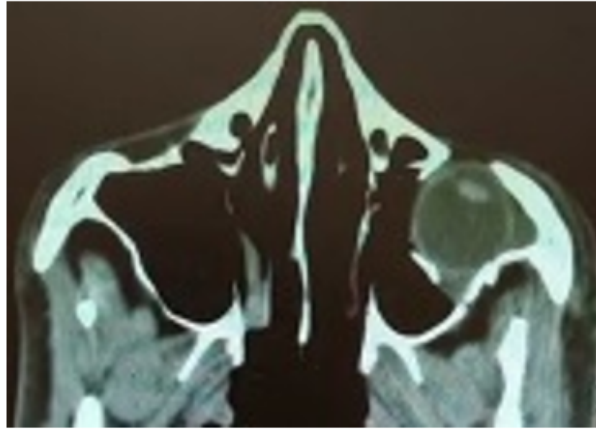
Orbital computed tomography (CT) scans showed downward displacement of the left globe to the adjacent maxillary sinus.
